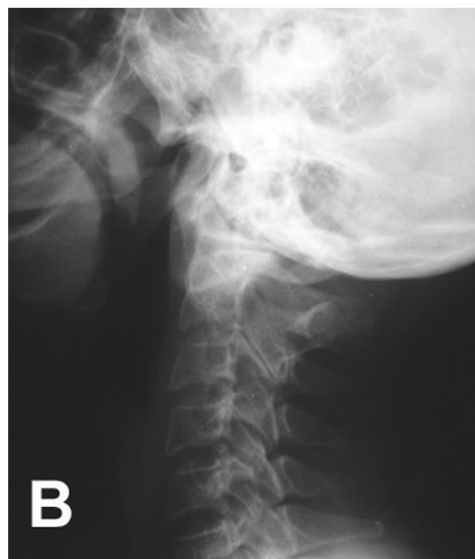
Six months after the injury, flexion (A) and extension (B) lateral radiographs of the cervical spine show fracture healing without any signs of instability.
